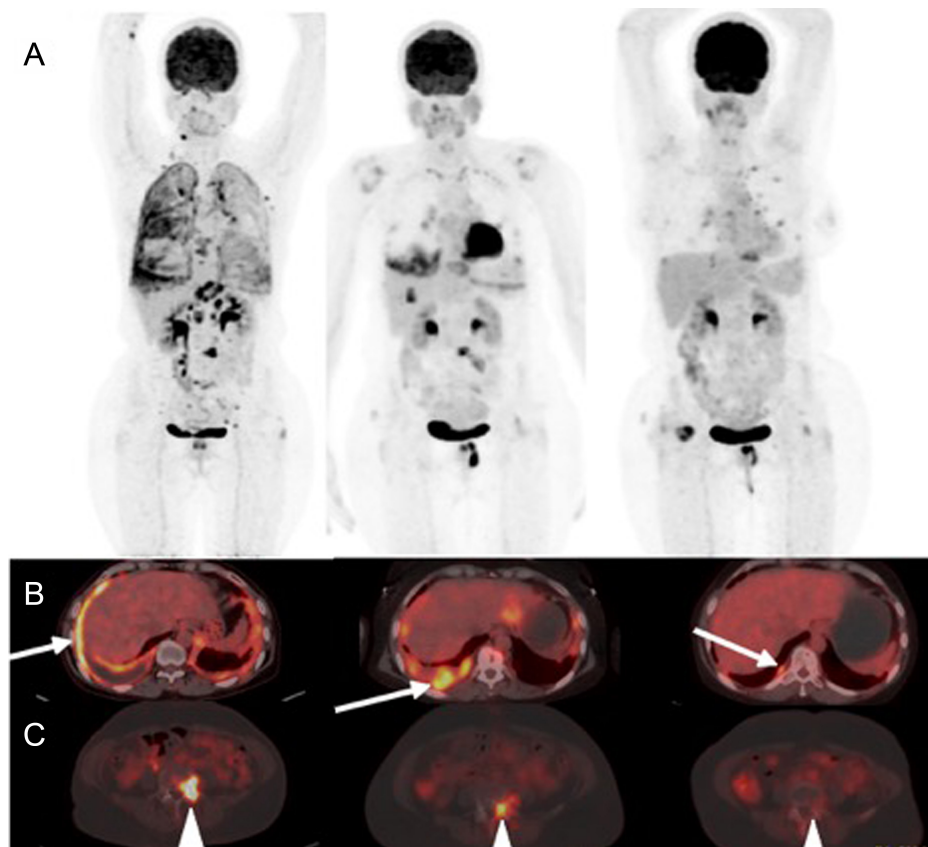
18-F FDG PET/CT scan showing EP TB in a 43-year-old female patient. Initial and after anti-TB treatment control PET studies are shown (left to right columns). Whole-body maximum intensity projection images are shown (A). Trans-axial fused images showing FDG-avid pleural (B; arrows) and bone lesions (C; arrowheads) regression after anti-TB treatment. CT, computed tomography; EP, extrapulmonary; 18-F FDG, fluoro-2-deoxy-D-glucose; FDG, fluorodeoxyglucose; PET, positron emission tomography; TB, tuberculosis.
